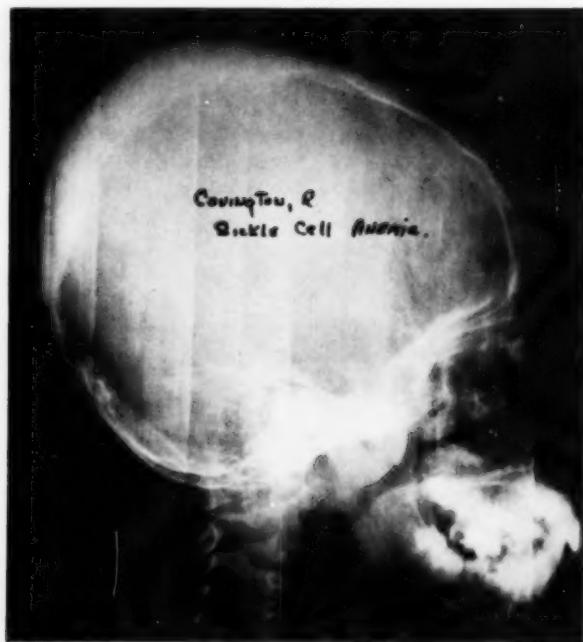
Skull X-ray showing "hair-on-end" appearance, thin and porous anterior table and increased diploic spaces.
